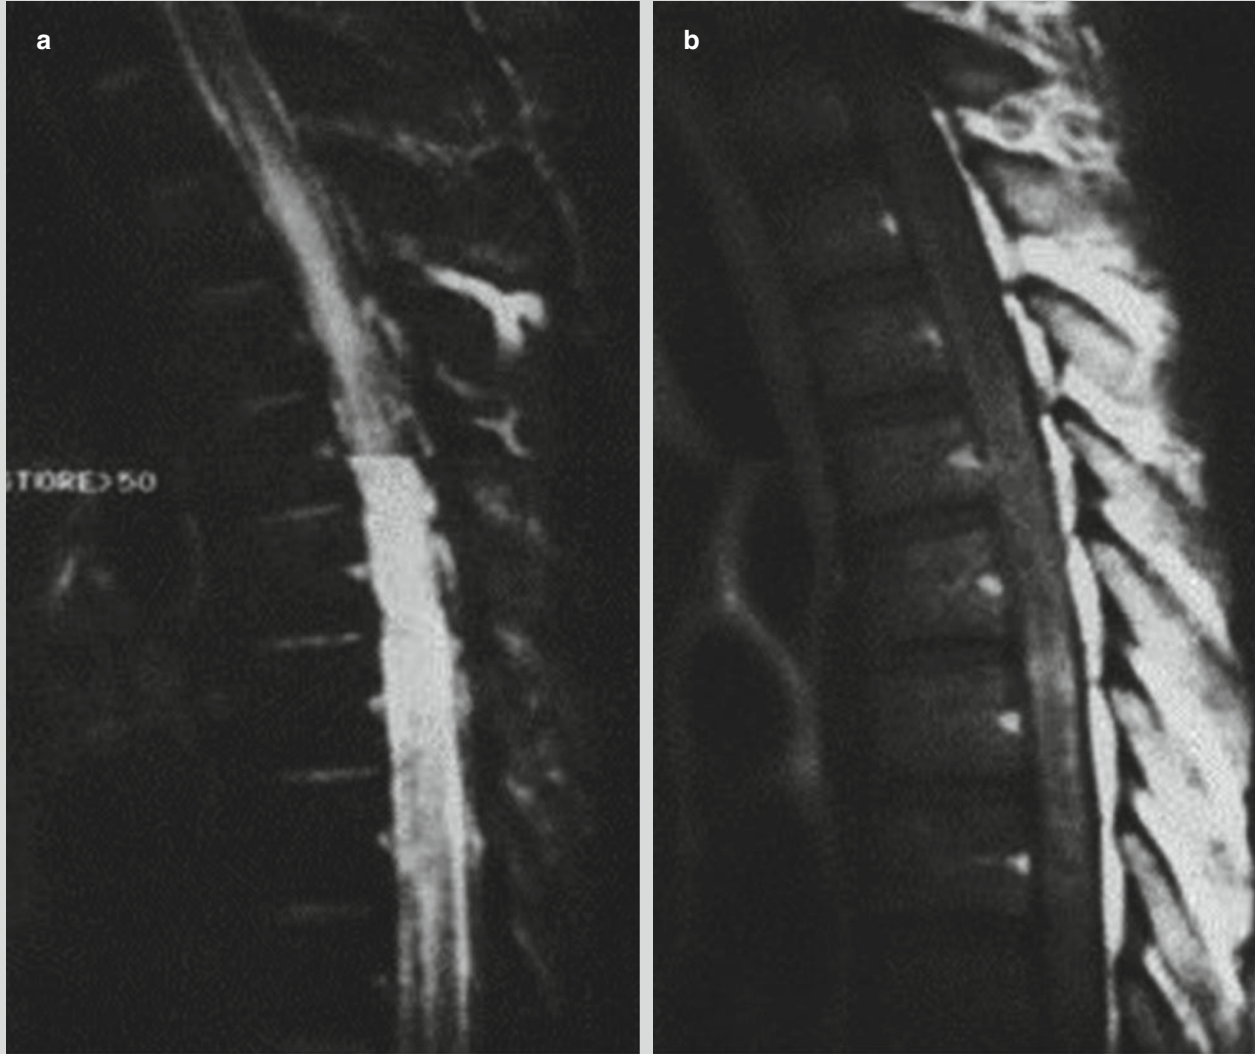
Syphilitic myelitis. (a) Sagittal T2WI of MRI demonstrates high signal at the thoracic spinal cord. (b) Gd-DTPA contrast sagittal T1WI demonstrates uneven enhancement of the thoracic
